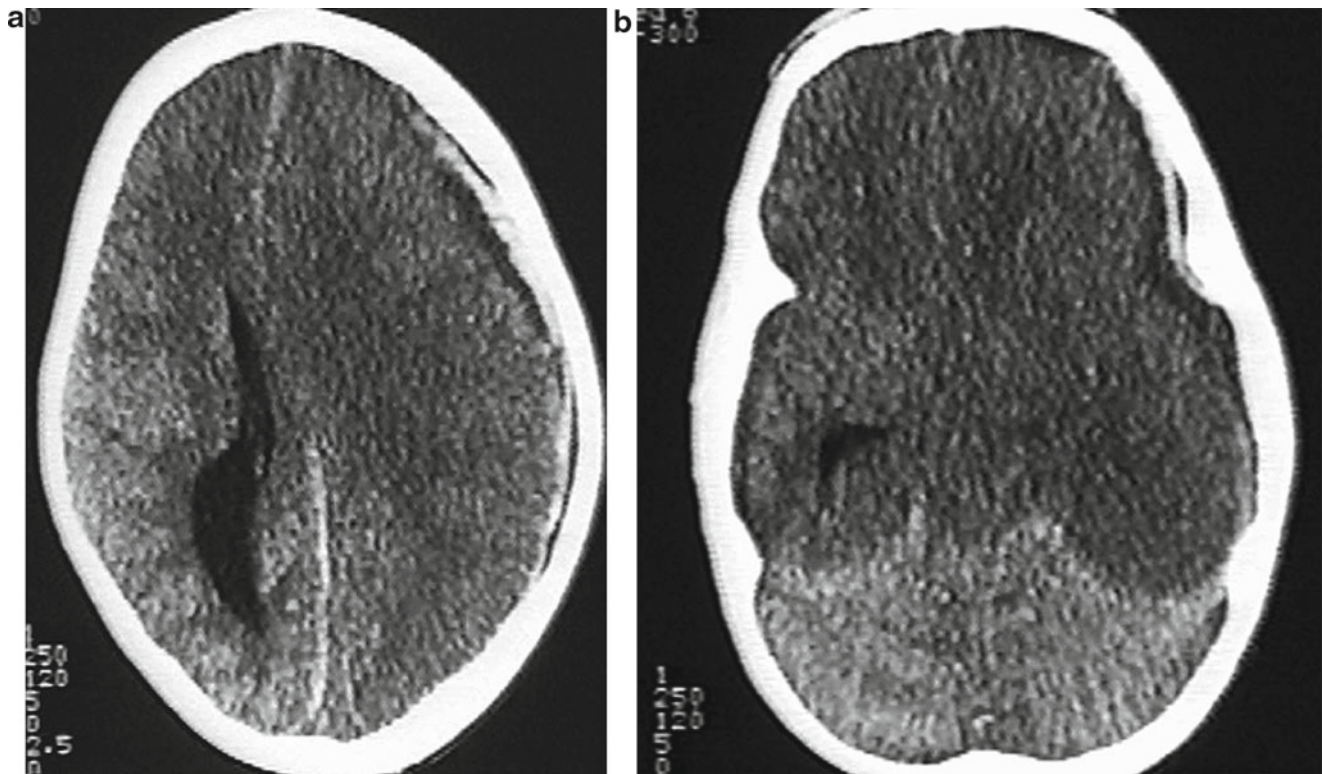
Seven-week-old infant presented with respiratory insufficiency and unresponsiveness; CT with large, acute left subdural hemorrhage, shift to midline, cerebral edema, and layering of acute hemorrhage along (a) falx cerebri and (b) tentorium
